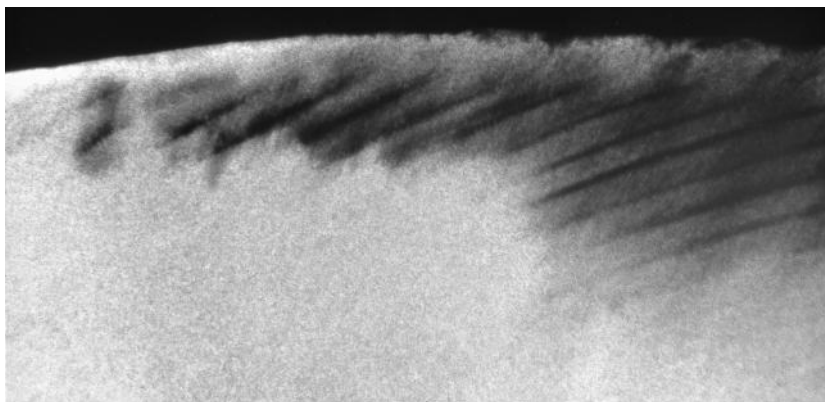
When sections are examined by X-rays (microradiography) the calcium loss is directly shown as darker areas in the otherwise white, highly mineralized enamel. Note how the surface enamel varies in mineral content, but is better mineralized than the body of the lesion.
